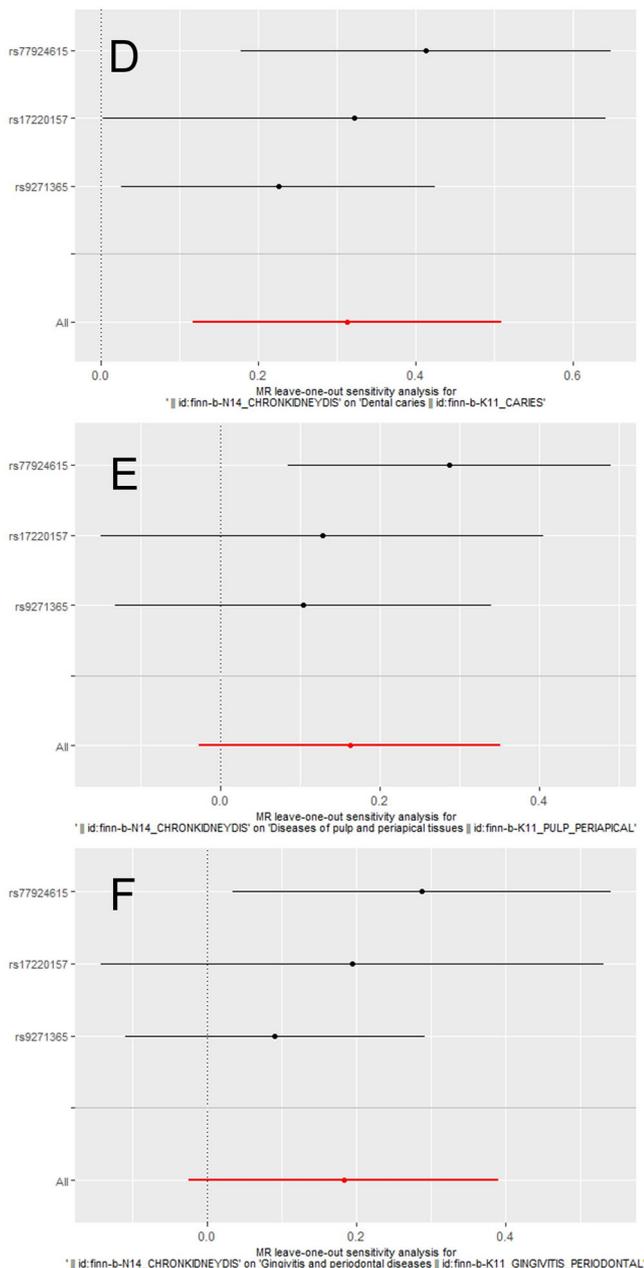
MR leave-one-out sensitivity analysis of CKD and oral diseases. (D) Leave-one-out analysis of CKD and dental caries. (E) Leave-one-out analysis of CKD and diseases of the pulp and periapical tissues. (F) Leave-one-out analysis of CKD and diseases of the gum and periodontal tissues. Leave-one-out analysis showed that the results did not change much after removing any SNP, and the results of MR analysis were robust without potential bias.
